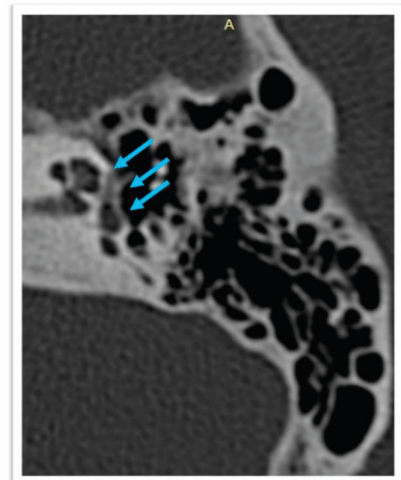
Axial CT images of the temporal bones with grade 2C otosclerosis in a 59-year-old male patient, noticing an irregular reduction in the usual bone density around the lateral aspect of the basal, middle and apical turns of the cochlea (blue arrows).
